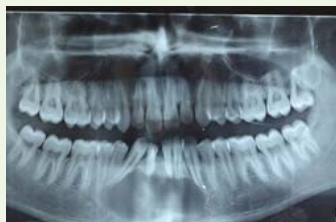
X-ray OPG before treatment
